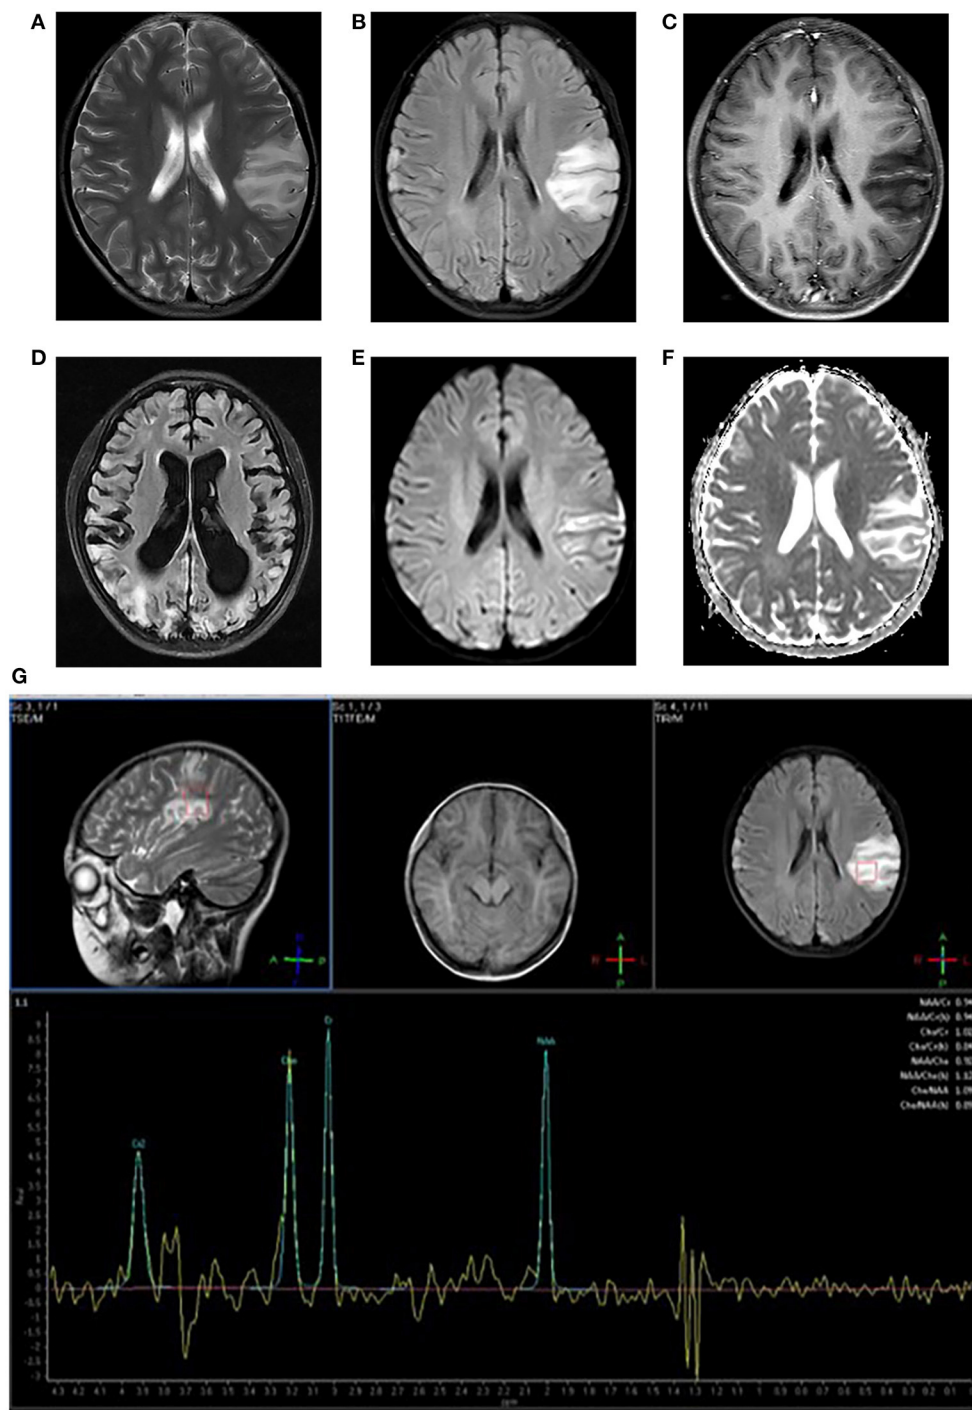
Neuroimaging for an 8-year-old girl with MELAS who presented with intermittent fever, vomiting, convulsions. (A,B) Axial T2WI and T2FLAIR imaging reveal multiple hyperintensities in bilateral frontal and parietal cortex and subcortical white matter, especially in the left side; (C) Axial post-contrast T1WI imaging reveals linear enhancement of the left lesions; (D) T2FLAIR image 3 years later demonstrates new migrating lesions of both cerebral hemispheres along with old lesions, accompanied by evolving encephalomalacia, atrophy; (E) DWI imaging demonstrates hyperintensities in gyriform pattern in the lesion areas; (F) ADC sequence shows iso/hyperintensities corresponding to DWI lesions; (G) MRS imaging shows decreased NAA/Cho ratio and a large lactate peak.
